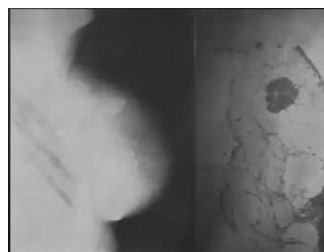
Lockwood H. The value of Breast Radiography. Radiology 1934-23(2)-202-207
